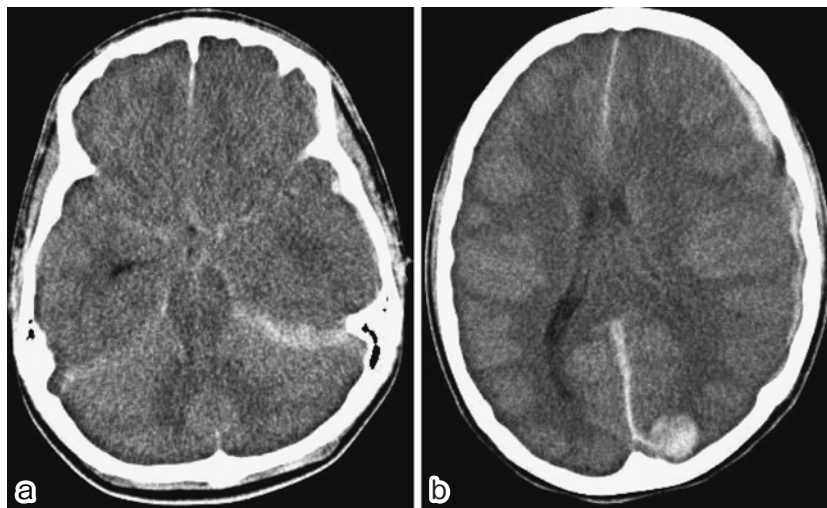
Initial computed tomography (CT)
